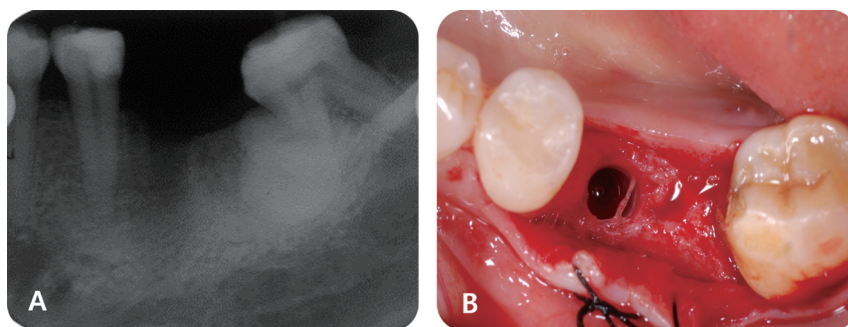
The implant was removed due to the significant mobility during open flap debridement around the lesion. Periapical radiograph (A) and clinical photograph (B) after the explantation.
